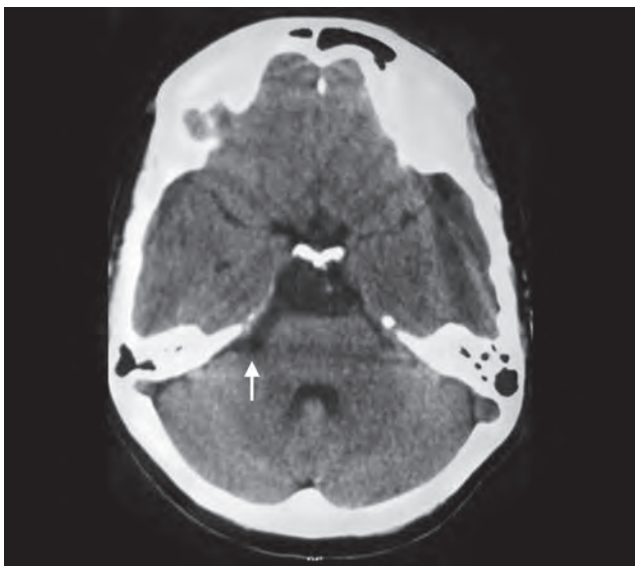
CT scan of the brain showing CP angle epidermoid (white arrow) with extension into the prepontine cistern
